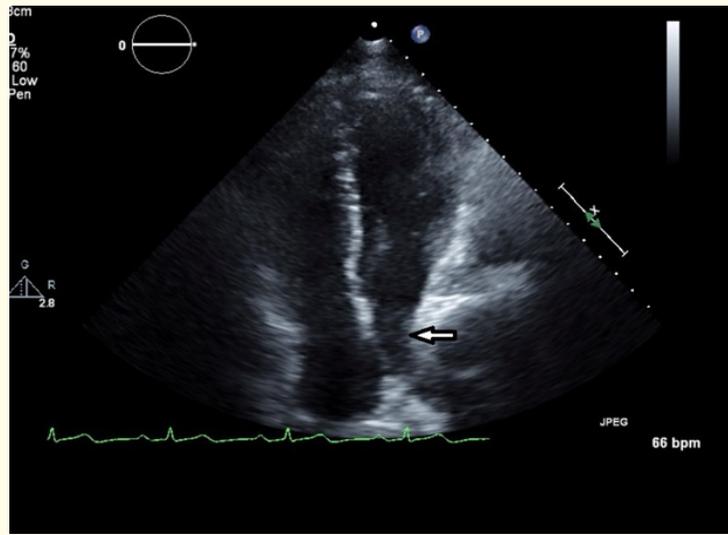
Transthoracic echocardiogram showing decreasing left atrial size.
